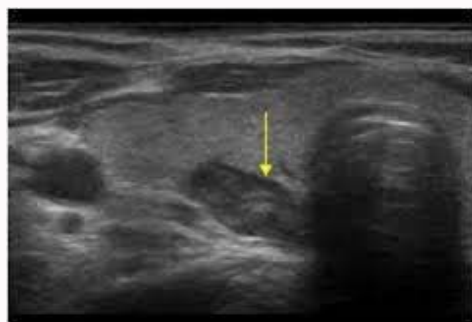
Inferior Parathyroid Adenoma. On ultrasound, parathyroid adenomas are usually well-circumscribed, ovoid, and longitudinal in shape. They are homogeneously hypoechoic relative to the thyroid echogenicity.
